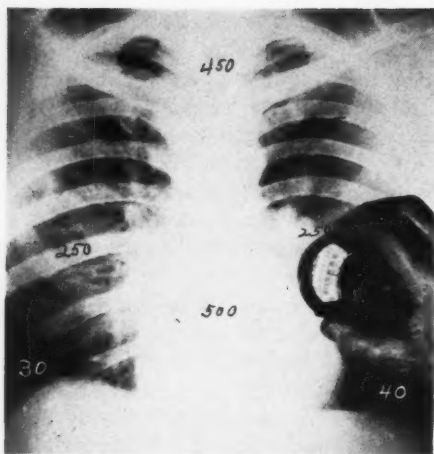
Photometer held over roentgenogram to detect the increased lung densities with mathematical accuracy. This roentgenogram shows increased lung density in the mid-lung field.
